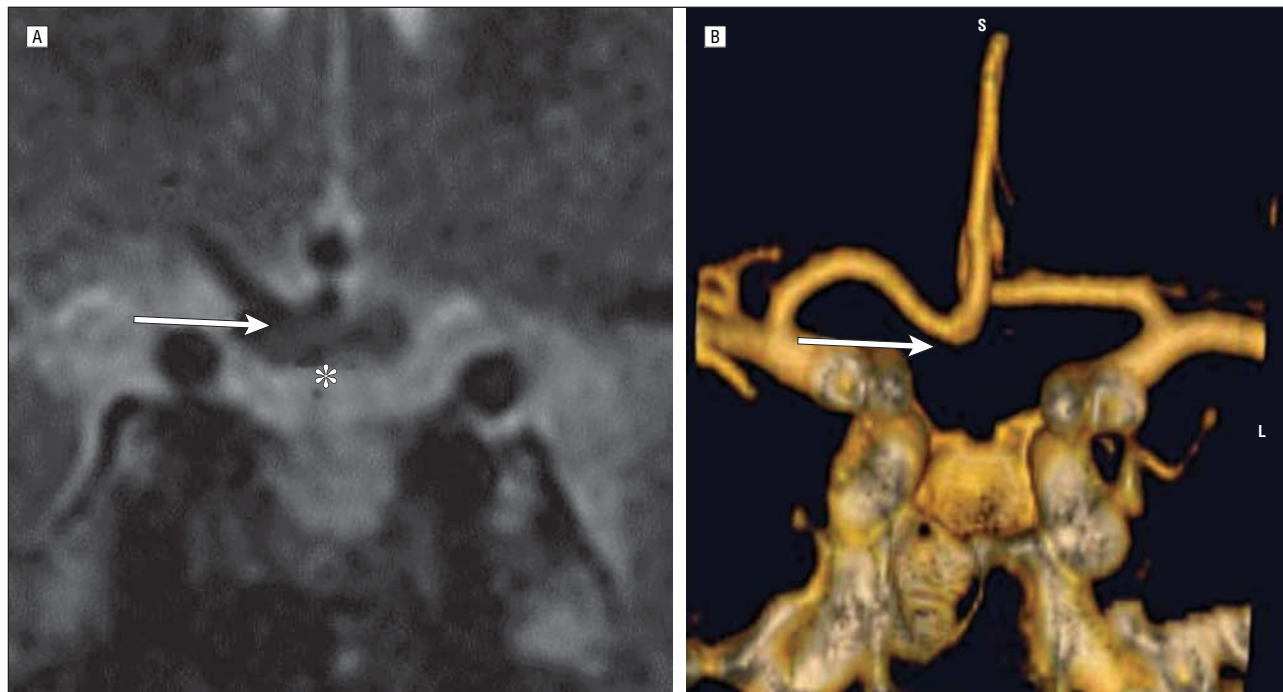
A, T2-weighted coronal magnetic resonance imaging showing impingement and downward displacement of the optic chiasm (asterisk) by a vessel (arrow). B, Reconstructed coronal computed tomographic angiography shows an elongated right anterior cerebral artery that curves downward, forming a loop (arrow) that corresponds to the point of contact with the optic chiasm. The opposite anterior cerebral artery has a normal structure.
